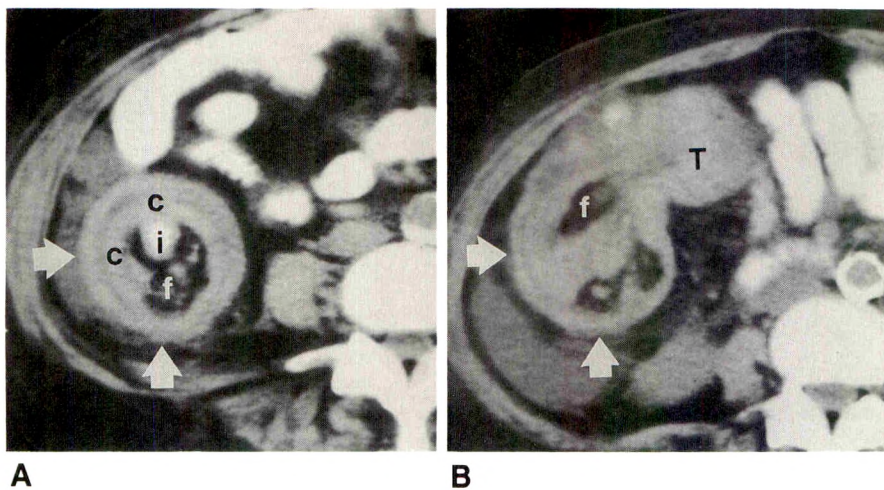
CT scans of ileocolocolic intussusception due to cecal carcinoma.
